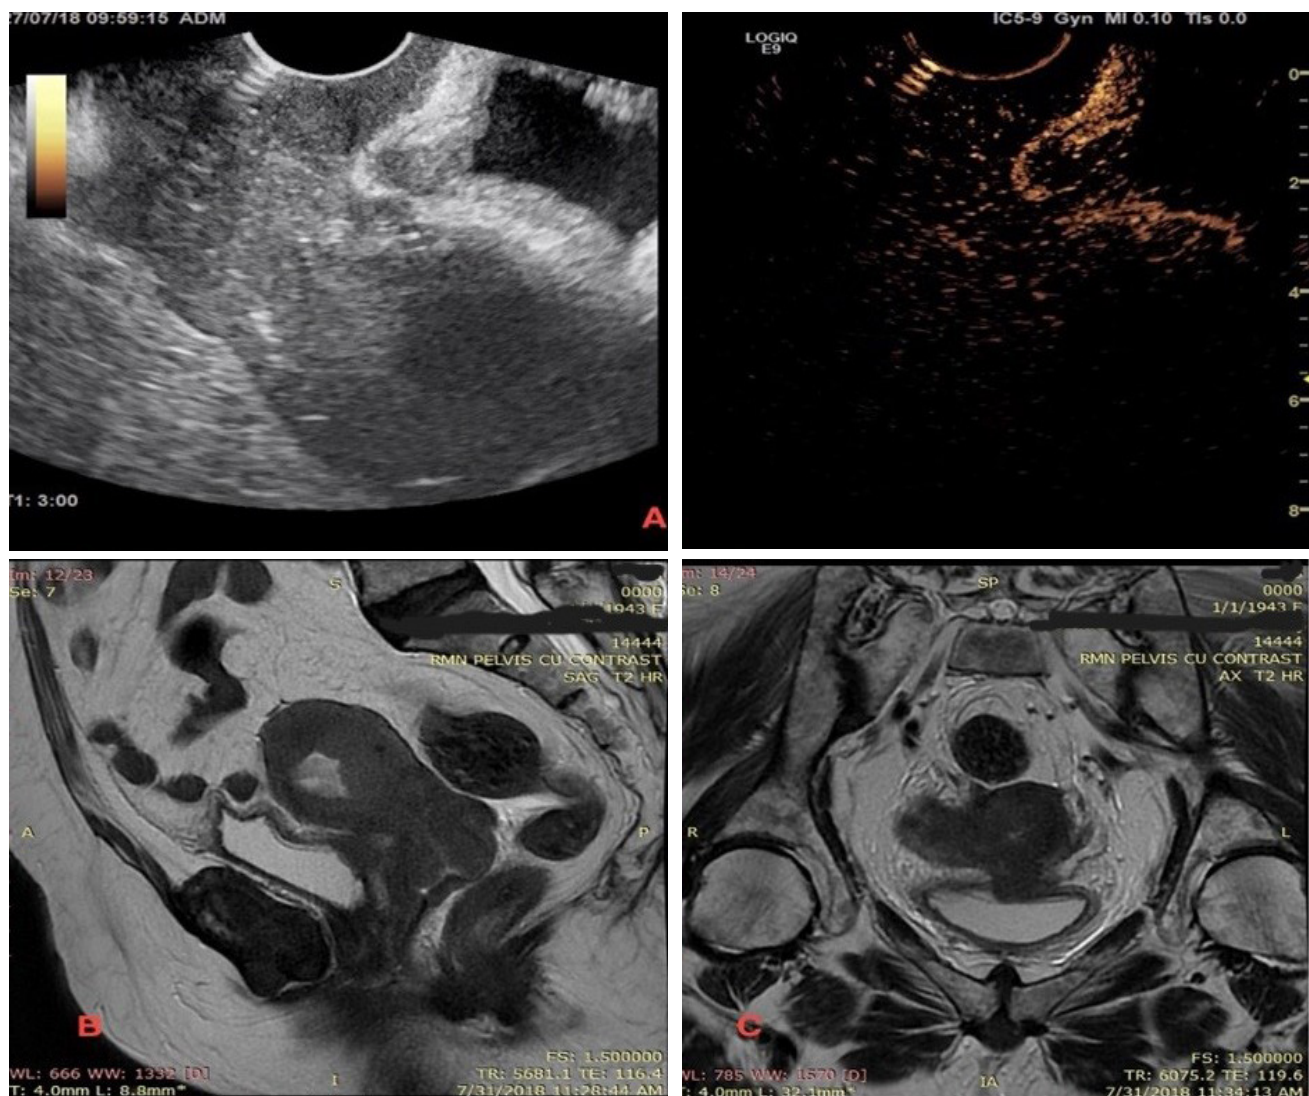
A. CEUS in patient KS, 76 years old, stage IVA cervical cancer. Sagittal grayscale image (left) and CEUS image 3 minutes after SonoVue injection. Loss of bladder-cervical and cervico-uterine space contour with tumor infiltration of the entire bladder wall is seen. B. Sagittal MRI image in T2 sequence - tumour invasion into the vesico-uterine space with loss of bladder wall contour is observed. C. Axial T2-slice MRI image showing full bladder wall invasion.
